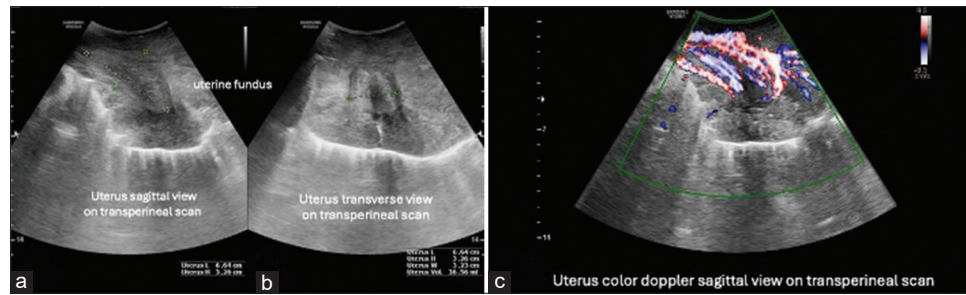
Sonographic findings of transperineal scan of vulvar mass. (a) Sagittal view. (b) Transverse view. (c) Doppler image demonstrating abundant color flow
